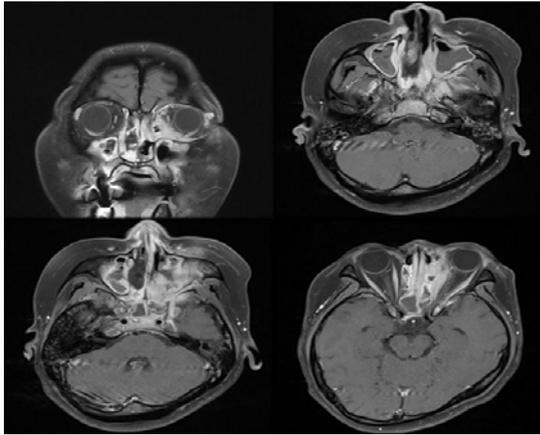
Brain MRI revealed enhancing and infiltrating lesions involved left nasal cavity, left ethmoid sinus, orbital apex and extra-conal region, left cavernous sinus, and meningeal of left anterior temporal base on T1-weighted image.
